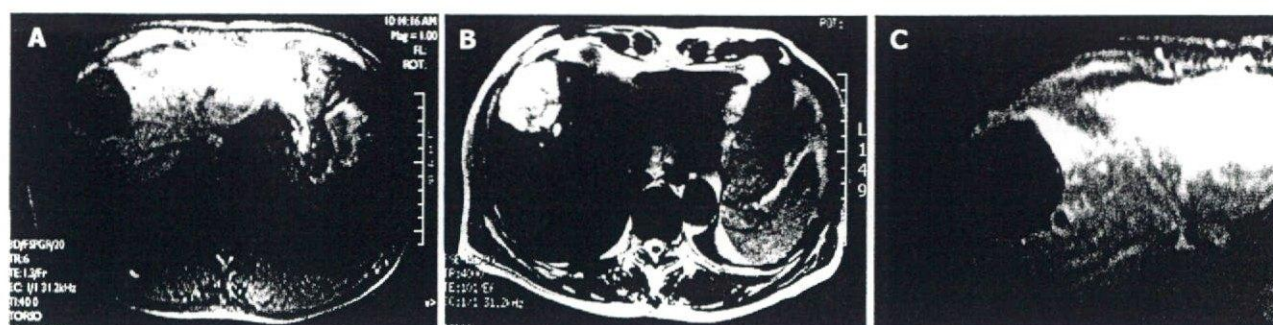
A low intensity signal on T1-weighted (A) and a high intensity signal on T2-weighted (B) images. The edge of the tumor was slightly enhanced by gadolinium, while the inside was heterogeneous (C).
